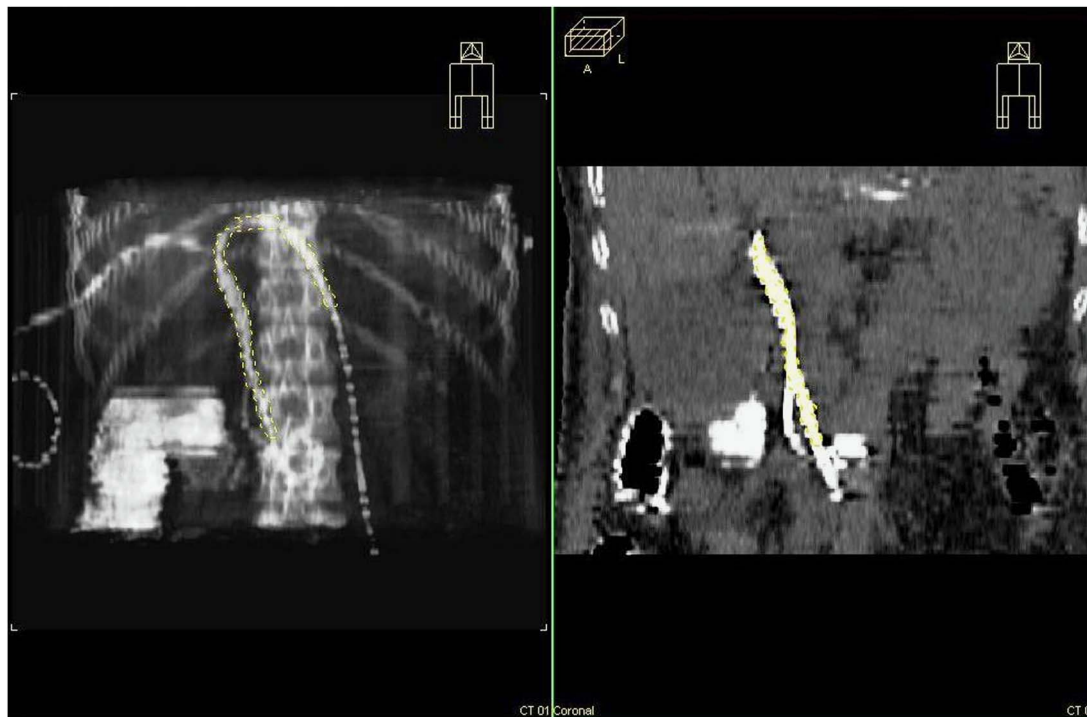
Corrected reconstruction using digitally reconstructed radiograph.
